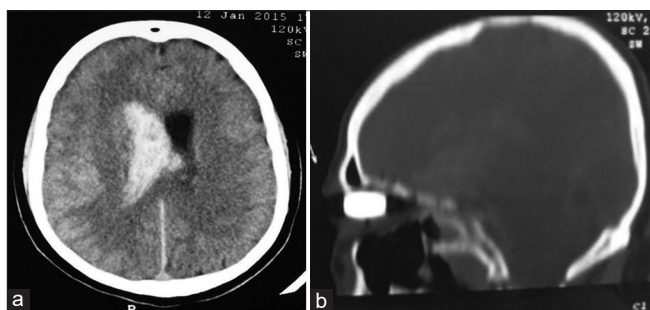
(a) A cranial computed tomography (CT) scan (Axial section) reveals intraventricular hemorrhage in the right lateral ventricle extending to the left side. (b) A cranial CT scan (Sagittal view) shows the bullet's settlement in the orbit.
